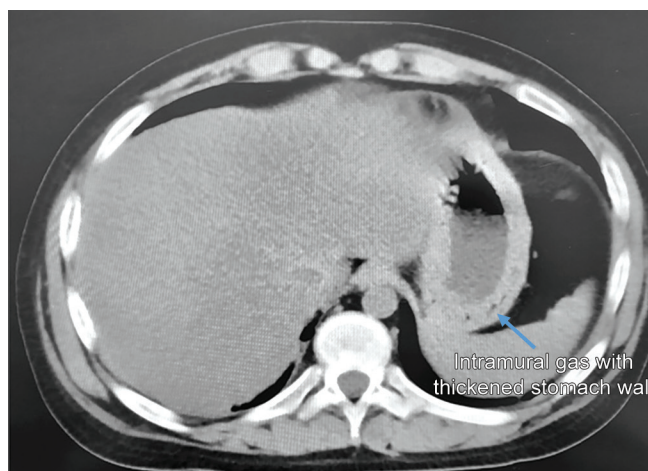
Computed tomography suggestive of gastric wall thickening with intramural gas
